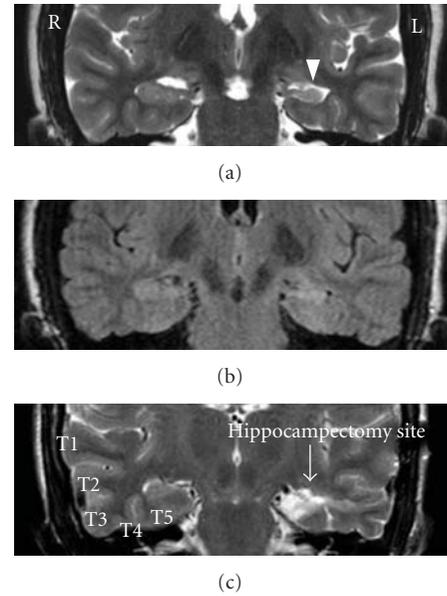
((a) and (b)) Coronal T2 and FLAIR magnetic resonance image (MRI) respectively depicting a left mesial temporal sclerosis. (c) Coronal T2 MRI depicting hippocampectomy site after selective amygdalohippocampectomy on left and temporal gyri (superior (T1), middle (T2), and inferior (T3) gyri, the fusiform gyrus (T4), and the parahippocampal gyrus (T5)) on right side.
